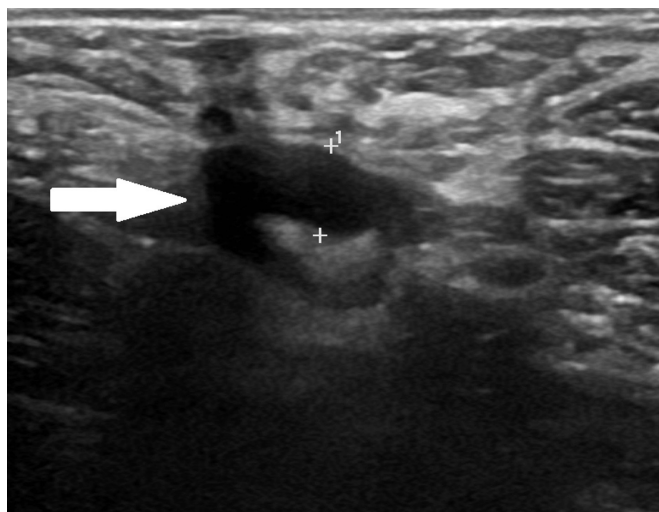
Right axillary ultrasound showed an enlarged axillary lymph node with a 0.6 cm hypoechoic cortex with mild hilar displacement (arrow) corresponding to the palpable and mammographic mass.
